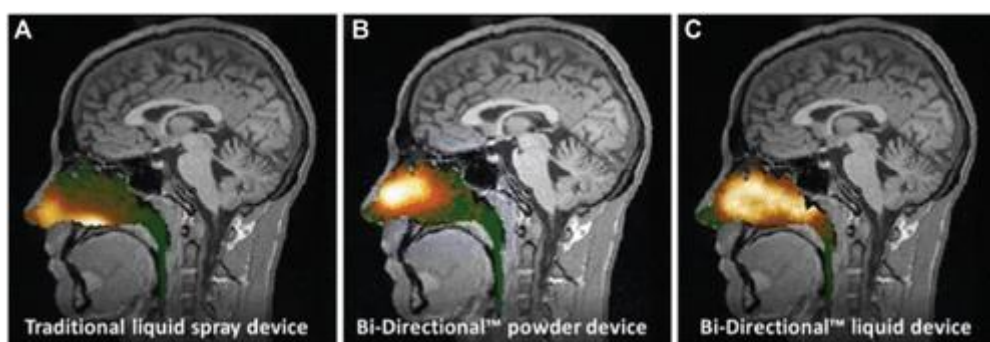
Gamma camera image data from the nasal cavity superimposed on the corresponding sagittal MRI section showing deposition two minutes after delivery using (A) a traditional liquid spray, (B) a breath-powered powder device, and (C) a breath-powered liquid spray device incorporating the same spray pump. Djupesland et al. are reprinted (2012).
